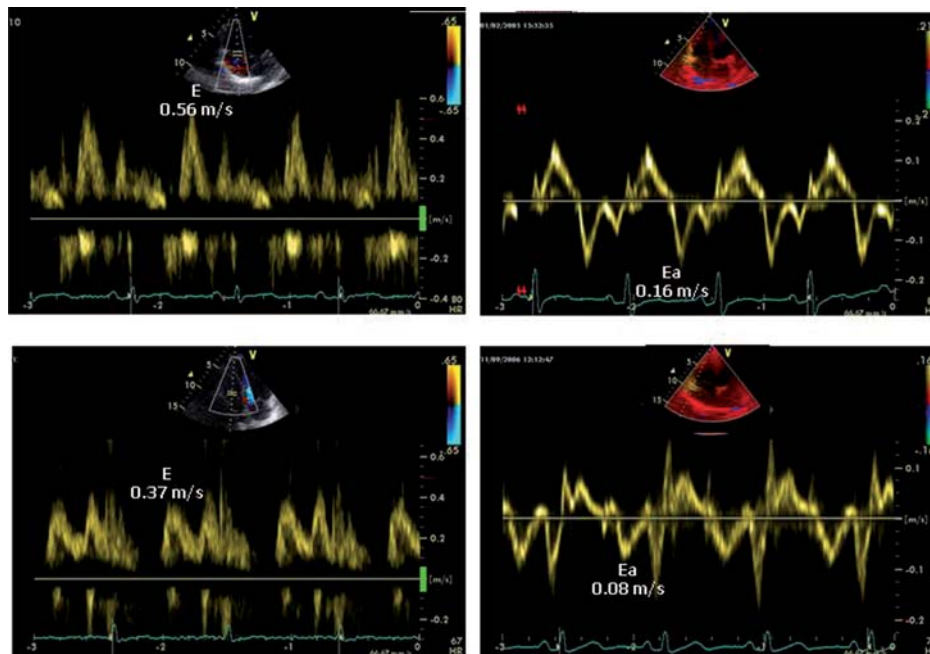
RV E/Ea ratio is 3.5 in a healthy 21-year-old subject (upper panel: left, Doppler tricuspid inflow pattern; right, pulsed Tissue Doppler of lateral tricuspid annulus) and 4.6 in a healthy 64-year-old subject (lower panel: left, Doppler tricuspid inflow pattern; right, pulsed Tissue Doppler of lateral tricuspid annulus).
